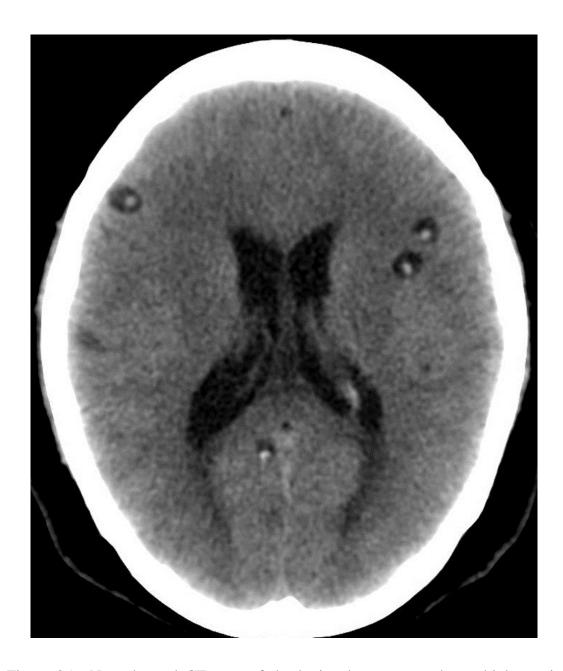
Nonenhanced CT scan of the brain, demonstrates the multiple cystic lesions with eccentric hyperattenuating scolex. No surrounding edema- vesicular stage of NCC.
